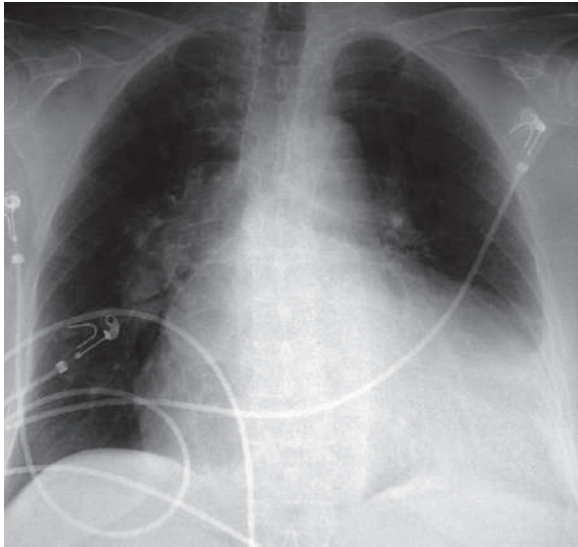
Anteroposterior chest radiograph of a bedridden patient shows massively dilated heart due to dilated cardiomyopathy (DCM)
